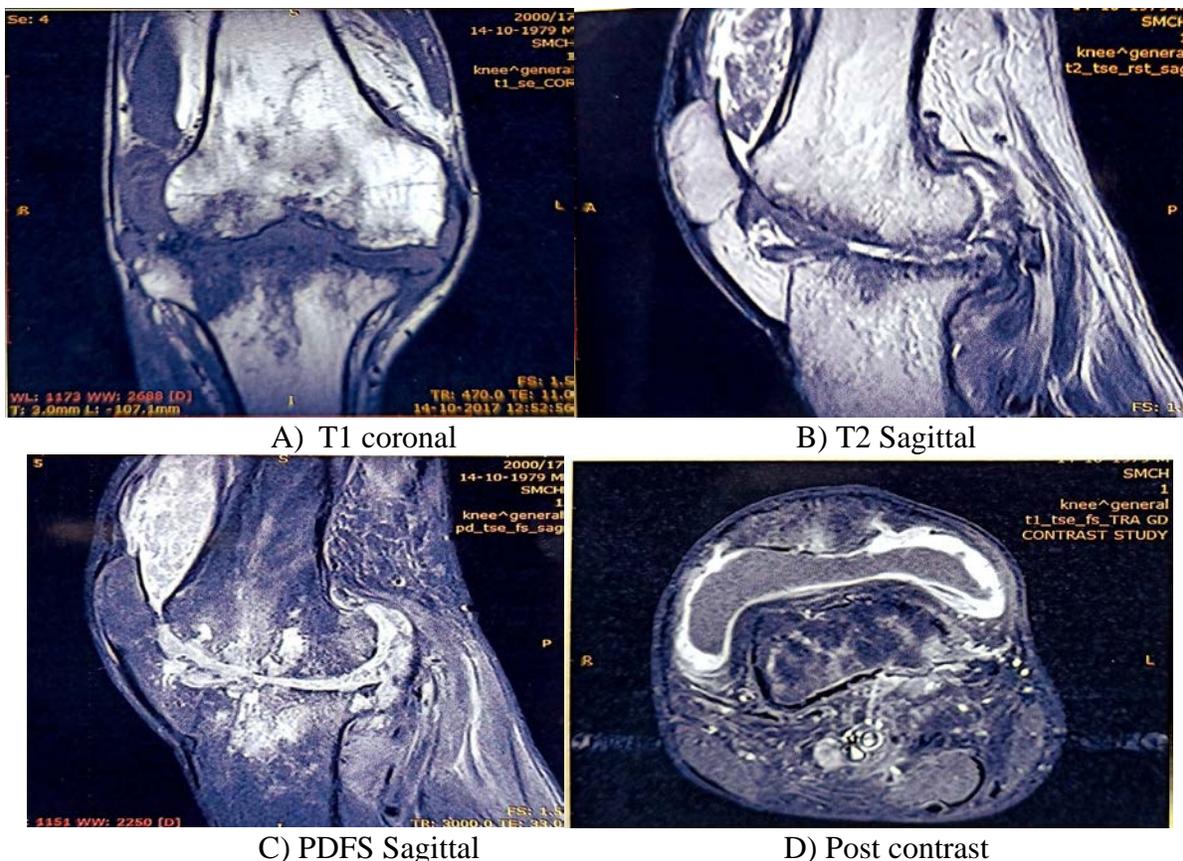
MRI shows erosions, joint effusion, synovial thickening demonstrating post contrast enhancement. PDFS hyperintensity suggesting bone marrow edema.
